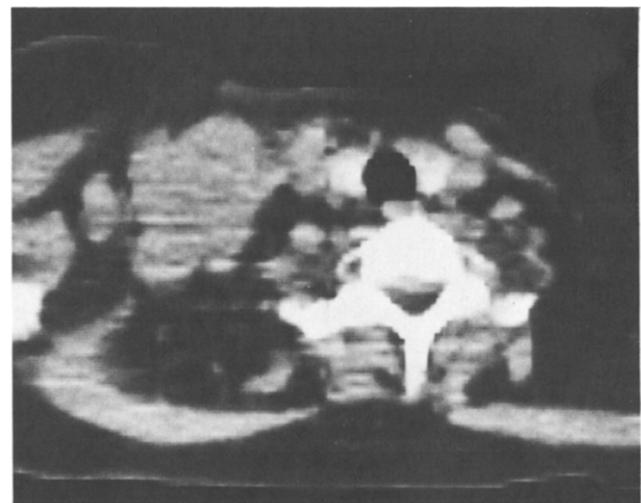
Unenhanced CT scan obtained at the same time shows the massive breast tumour with infiltrative growth into the right axilla.
